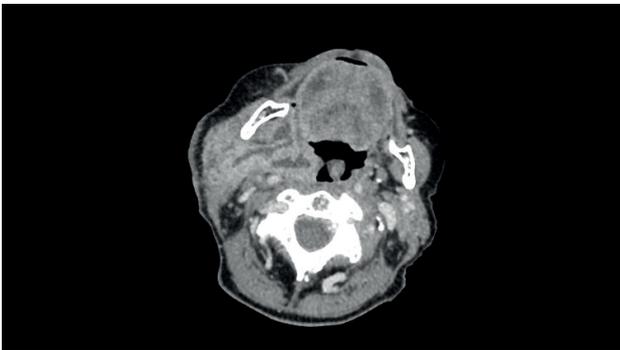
The CT scans of the neck with contrast revealed the enlargement of the right parotid gland with numerous fluid collections in both lobes and in the right parapharyngeal space.
